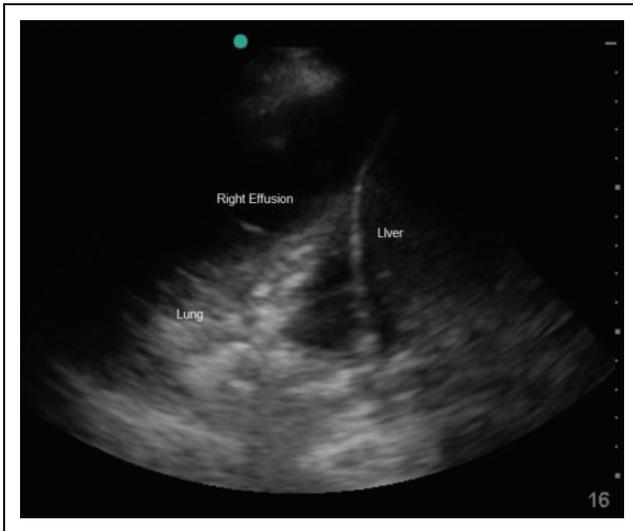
Ultrasound of the right pleural space.
